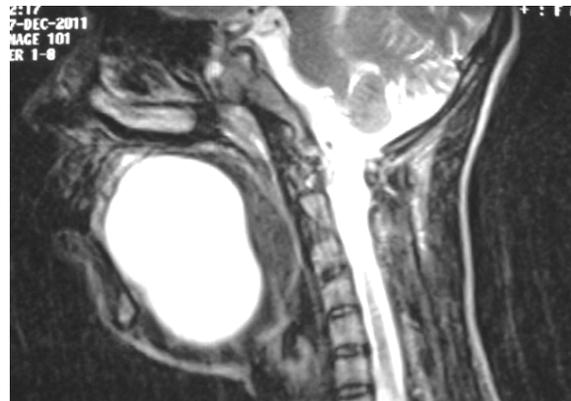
MRI (T2-weighted) showing hyperintense mass
